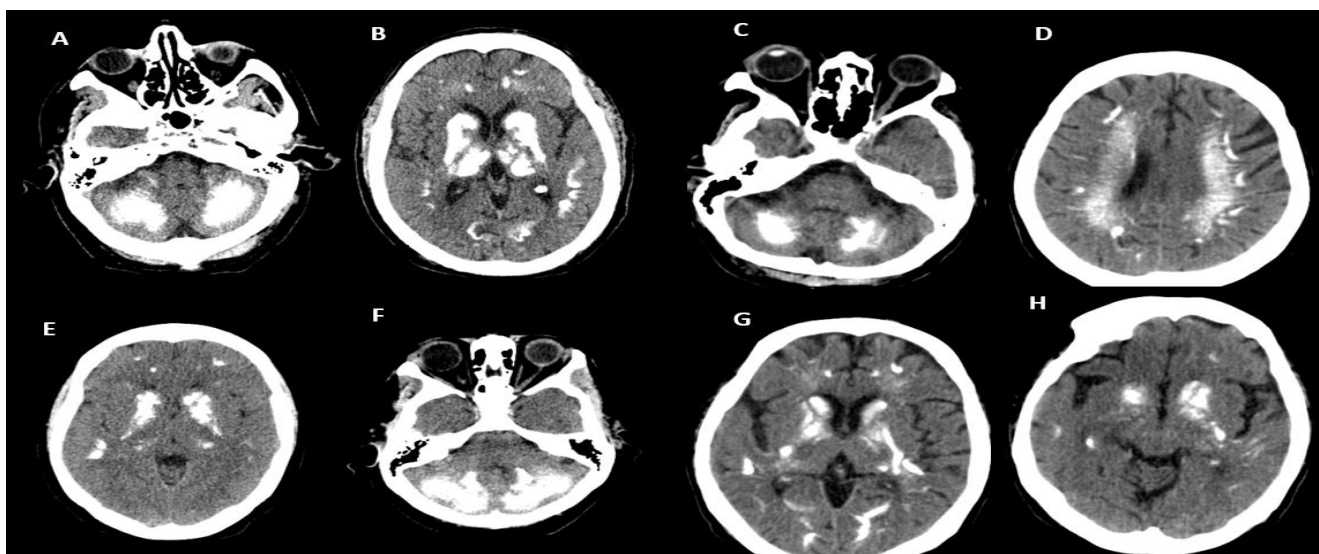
Brain CT scans demonstrating calcification patterns in Fahr's disease (A, C, F) axial CT images showing calcifications in the cerebellar lobes; (B, E, G, H) axial CT images revealing bilateral thalamic calcifications; (D) axial CT image depicting disseminated calcifications predominantly in the right cerebral lobes.
